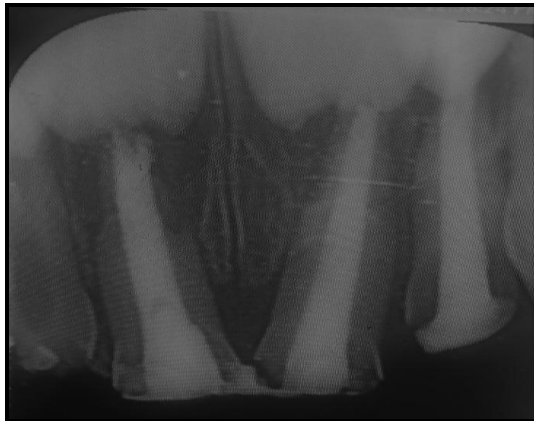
Radiographic representation of obturation with endoglas irt 51,52,61,54
